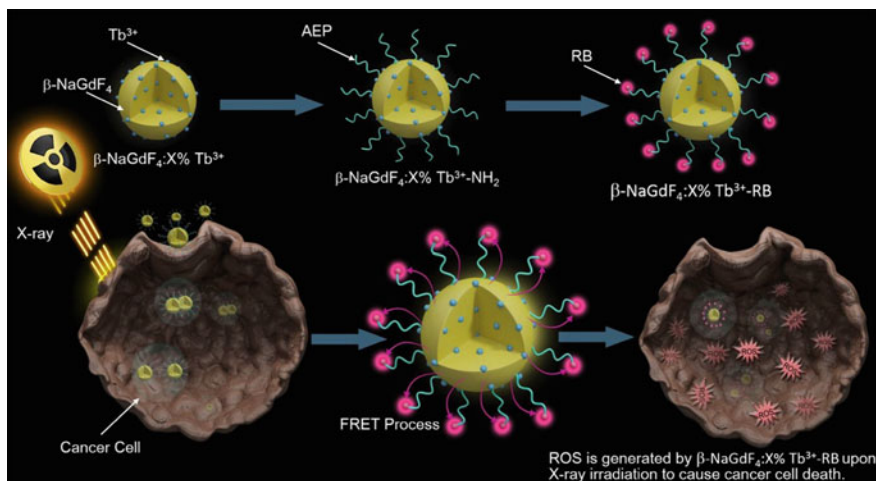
Graphical abstraction of materials synthesis and mechanism in X-ray based PDT [34]
